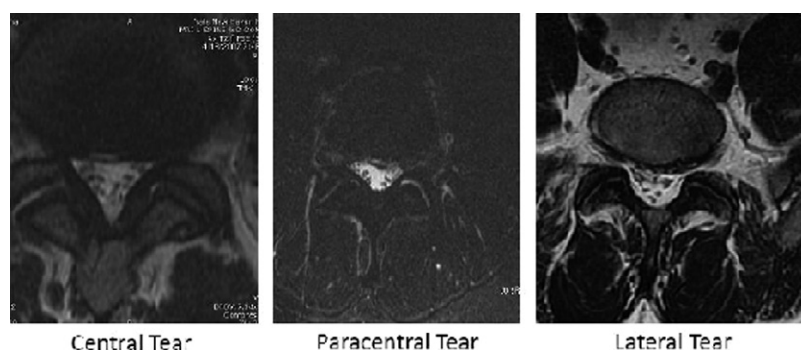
Examples of 3 different anatomic locations of annular tears on MRI: central, paracentral, and lateral. The location of annular tears was defined in the same way herniations of the intervertebral disc are defined.
